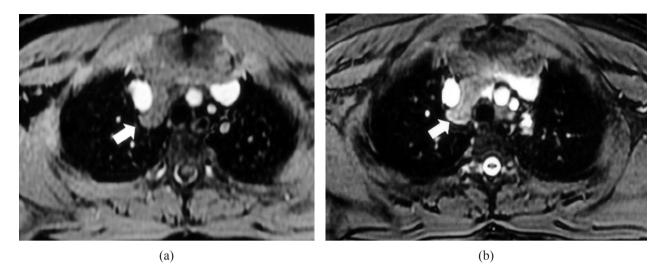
Contrast MRI showed an infiltrative lesion involving the superior and middle mediastinum at the right paratracheal region, about 4.5 cm at its greatest dimension, with iso-signal intensity on the T2-weighted image (a) and low signal intensity on the T1-weighted image (b).
